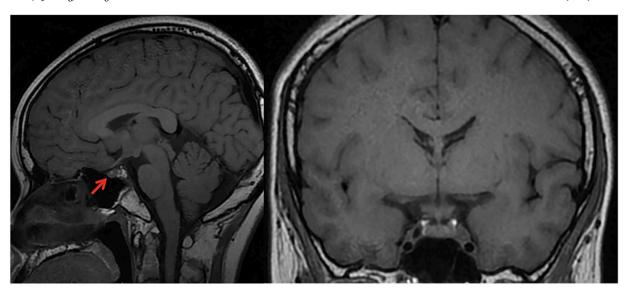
MRI Imaging. Contrast-enhanced MRI of the pituitary demonstrated an abnormal signal in the middle part of the pituitary gland (marked with red arrow).
